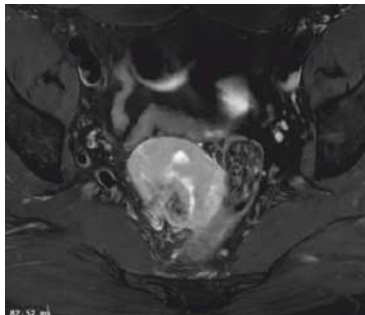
MRI showing pararectal mass
